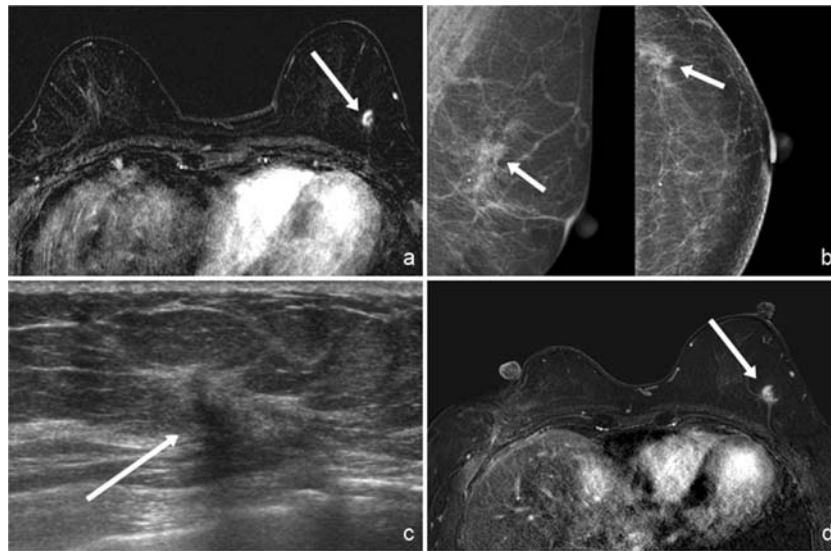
A 63-year-old woman with a delayed diagnosis of contralateral breast cancer. a The initial preoperative T1-weighted early postcontrast subtraction axial MRI image shows a 10-mm circumscribed mass in the left upper outer breast (arrow), which was assessed as BI-RADS 3. b At a follow-up mammogram 1.1 years later, distortion was newly detected and a spiculated mass (arrow) at the left upper breast was identified. c US
